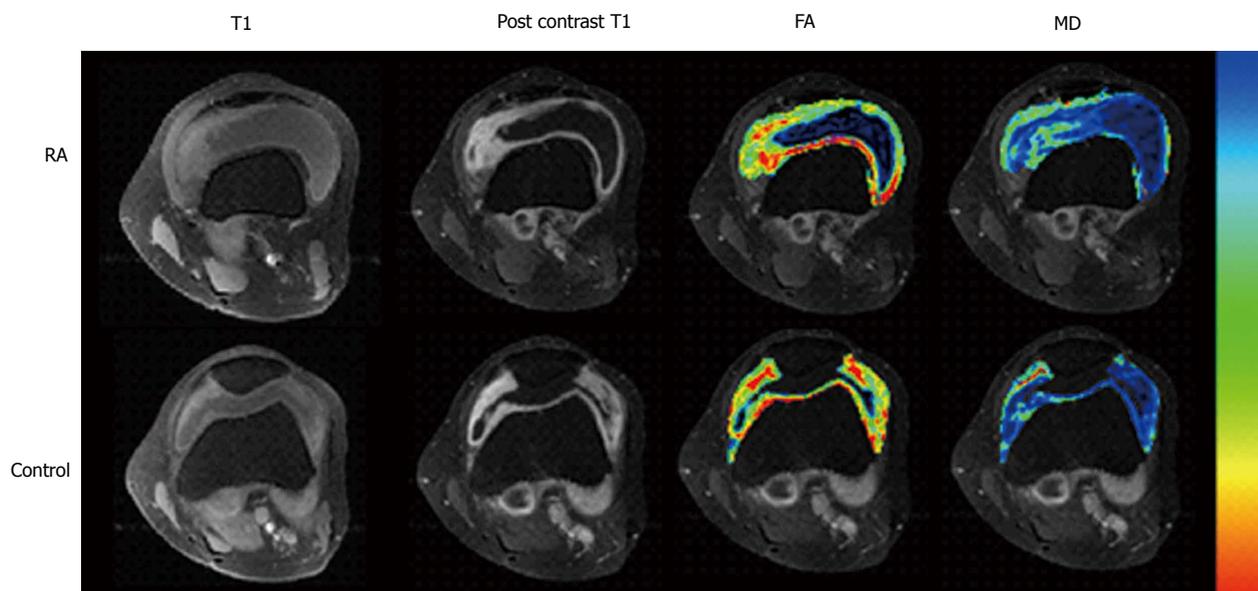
A 45-year-old male rheumatoid arthritis synovium shows strong enhancement on fat suppressed post-contrast T1-weighted axial image. Color coded fractional anisotropy (FA = 0.26) map from segmented region of enhanced synovial membrane overlaid on post-contrast fat-suppressed T1-weighted image show increased FA as compared to control (FA = 0.19). Mean diffusivity being inversely related to FA showed low values ($1.01 \times 10^{-3} \text{ mm}^2/\text{s}$). Color red denotes increased whereas blue denotes decreased values. RA: Rheumatoid arthritis; MD: Mean diffusivity; FA: Fractional anisotropy.
